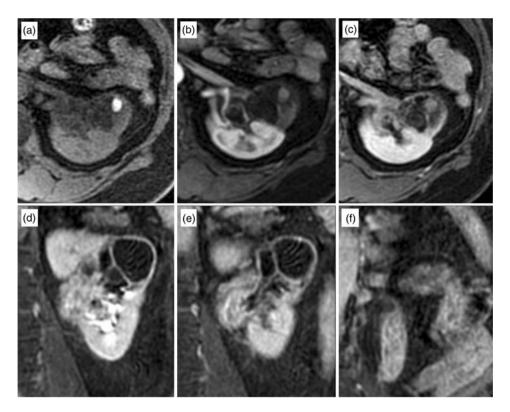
(a) Axial pre-enhanced, (b) axial arterial phase, (c) axial medullary phase fat-saturated T1-weighted MRI. Dynamic MRI study demonstrates delayed enhancement in the polypoid lesion and septa; (d, e, f) Continuous coronal excretory phase fat-saturated T1-weighted MRI showing marked enhancement in the polypoid lesion
